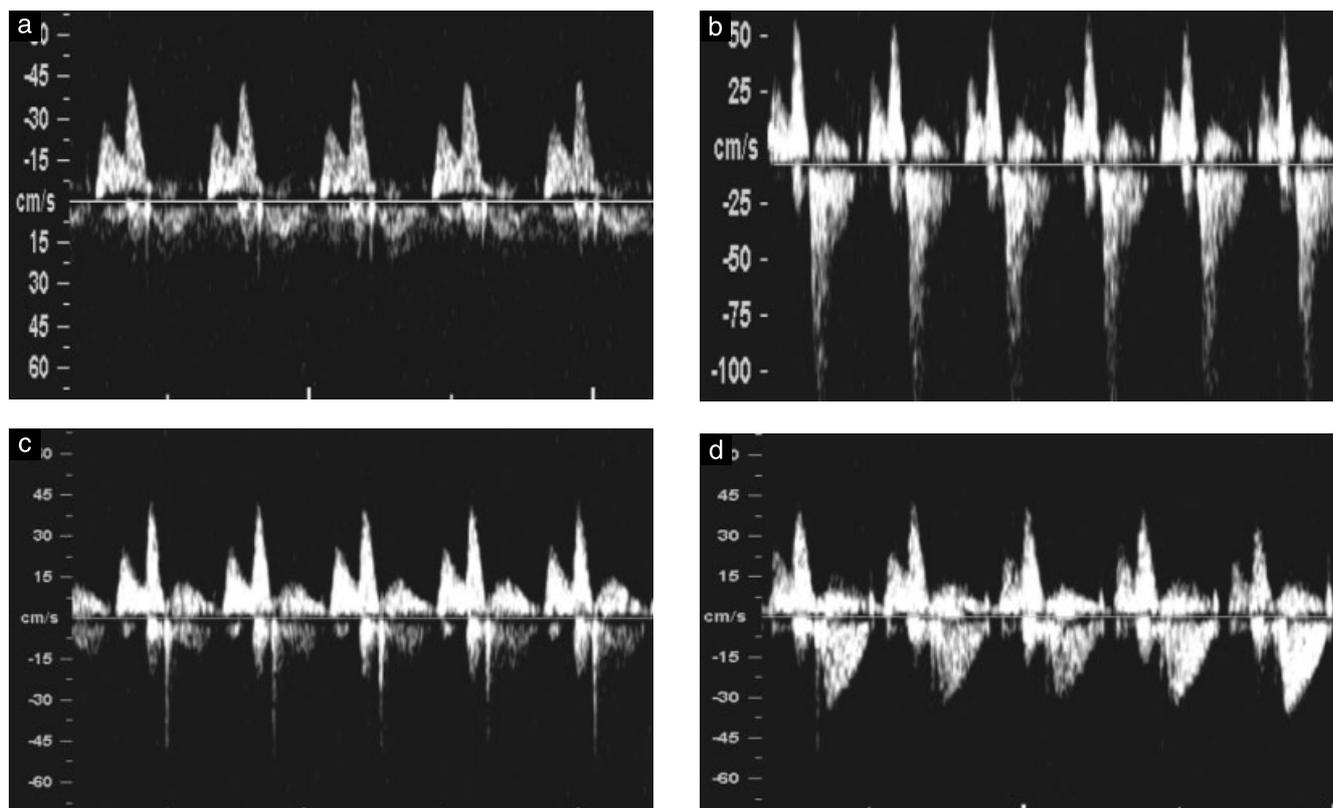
Doppler flow profile in the tricuspid valve with no regurgitation during systole (a), and regurgitation during approximately half of systole and with a velocity more than 80 cm/s (b). The short reverse 'spike' generated by the closure of the valve cusp (c) and the jet produced by aortic or pulmonary arterial blood flow, which at this gestation can produce a maximum velocity of 50 cm/s (d), should not be mistaken for tricuspid regurgitation.
